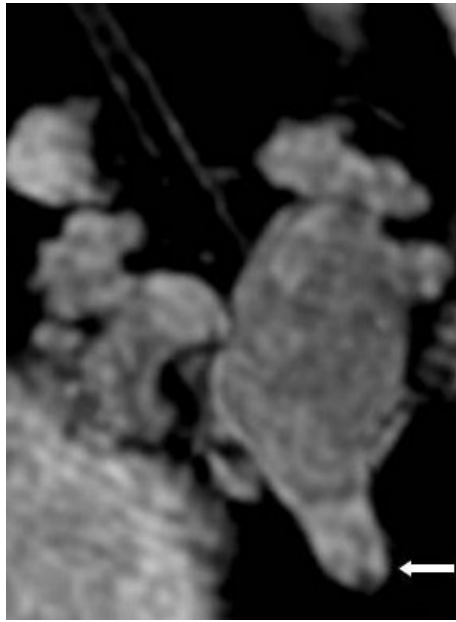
3D MRI Urography. Bilateral pelvicalyceal ectasia of kidney, bladder distention, key hole sing of proximal urethra (arrow).
